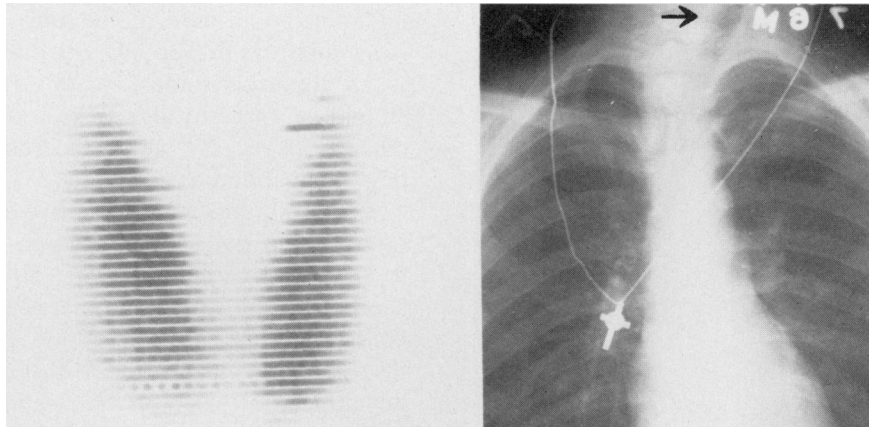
Thyroid scan of Case 2 showing enlarged gland and increased I^{131} uptake (left). Chest x-ray of Case 2 showing tracheal deviation from enlarged thyroid (arrow, right)
